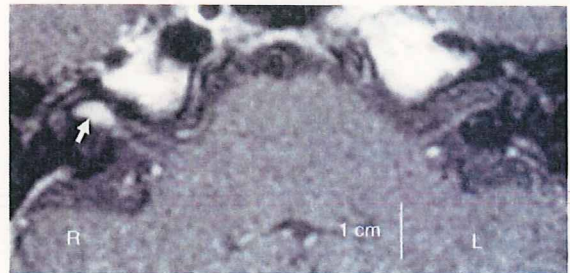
T1-weighted axial MRI enhanced by Gd-DTPA. There is a high intensity mass (white arrow, 6 mm in diameter) in the right internal meatus.
